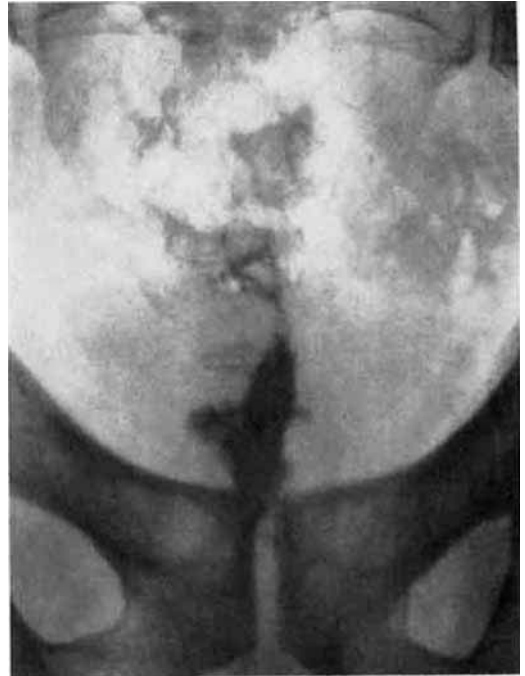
Roentgenograph of the pelvic inlet of the same subject as that of Fig. 3, 10 minutes after insertion of a type B suppository. The disintegration of the suppository and the spread of the contrast medium have hardly begun.
